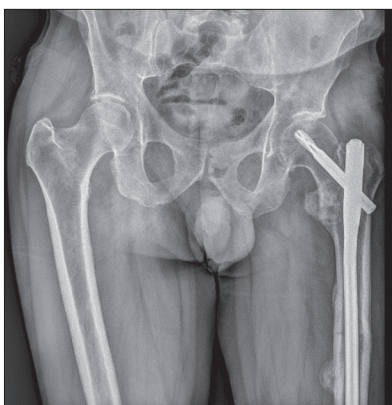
Radiography of the left hip and thigh two months after surgery [source: PACS Bežanijska Kosa UHMC]
